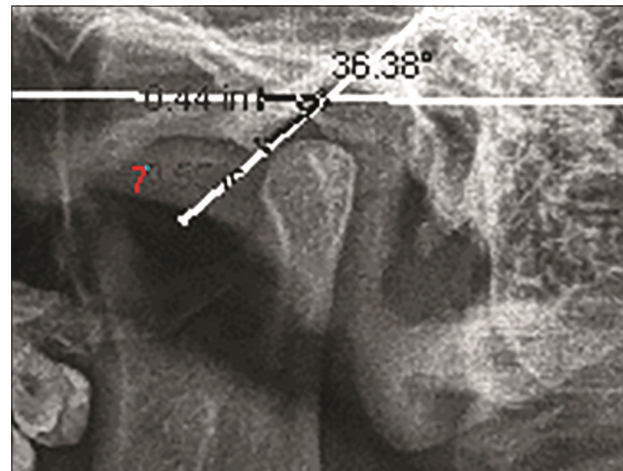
Orthopantomograph interpretation of a subject
